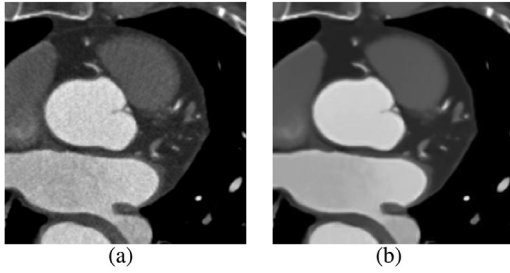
The denoised CTA image: (a) original CTA image slice; (b) denoised image.
